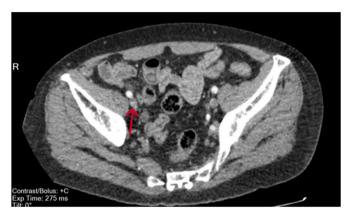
Enhanced CT suggested lower ureteral occupation with significant enhancement.
